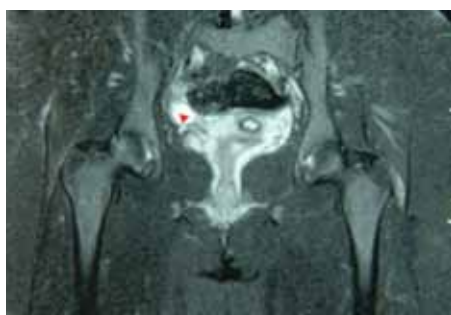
Coronal T2-weighted image after therapy demonstrates thin fluid signal intensity (red arrow head) adjacent to the tendon of the gluteus medius and total resolution of the large fluid collection
